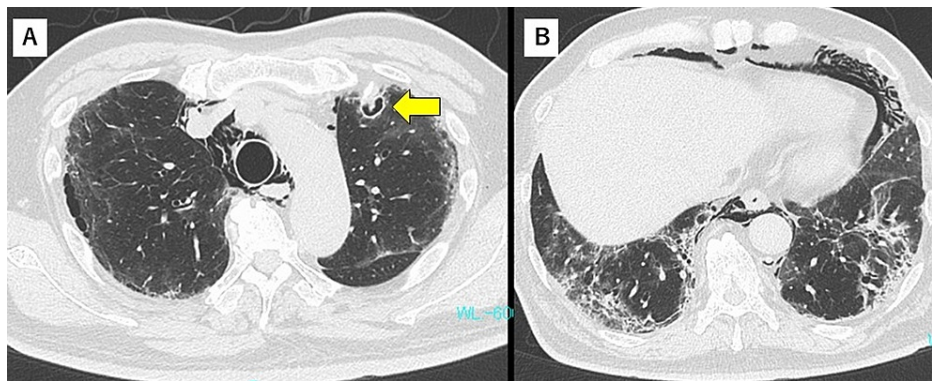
Chest CT findings on day 19
